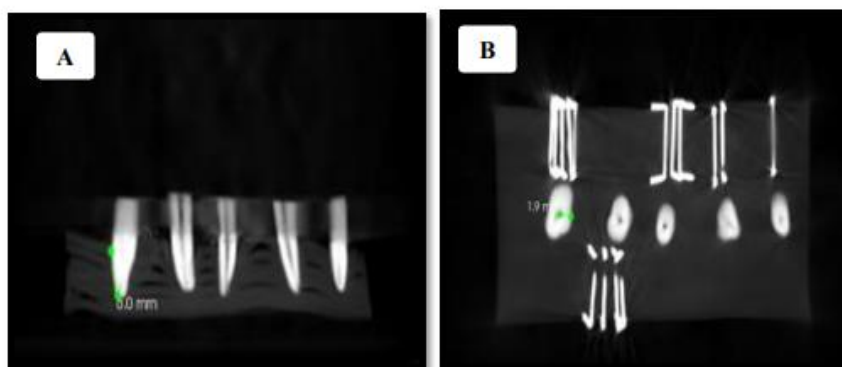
Evaluation of RDT using CBCT.
